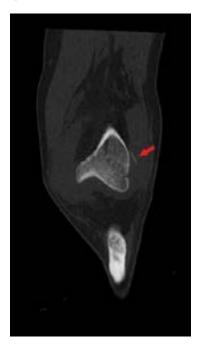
Non-contrast CT of the left knee in coronal section demonstrating a lateral distal femur avulsion fracture, also known as a Segond fracture (red arrow).
